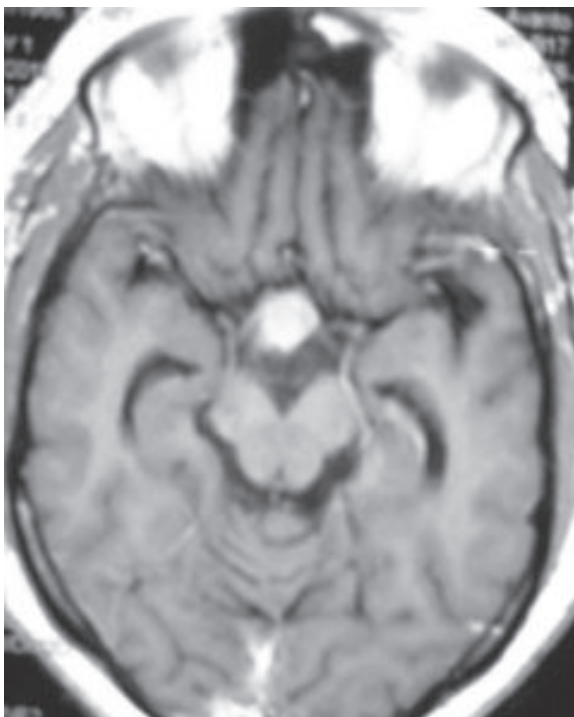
Preoperative MRI of brain with pituitary tumour with contrast (axial view)
